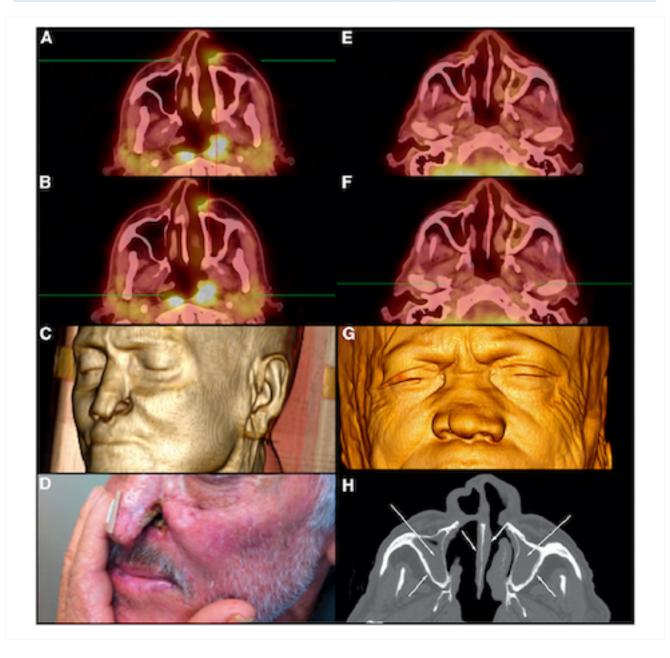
Mucosal leishmaniasis in 2 Brazilian patients. A-D: patient 1 with positron emission tomography/ computed tomography (PET/CT) images showing enhancement and subcutaneous thickening adjacent to erosion of the left nasal wing and obliteration of the posterolateral recess (A and B), 3D volume-rendered image of multislice CT data (3D CT) and picture with erosion of the left nasal wing (C and D). F-H: patient 2 with PET/CT images showing preserved glycolytic metabolism of facial structures (E and F), 3D CT with collapse of the nasal pyramids (G), and bone window CT with diffuse thickening of nasal wings and collapse of the nasal pyramid (H)
